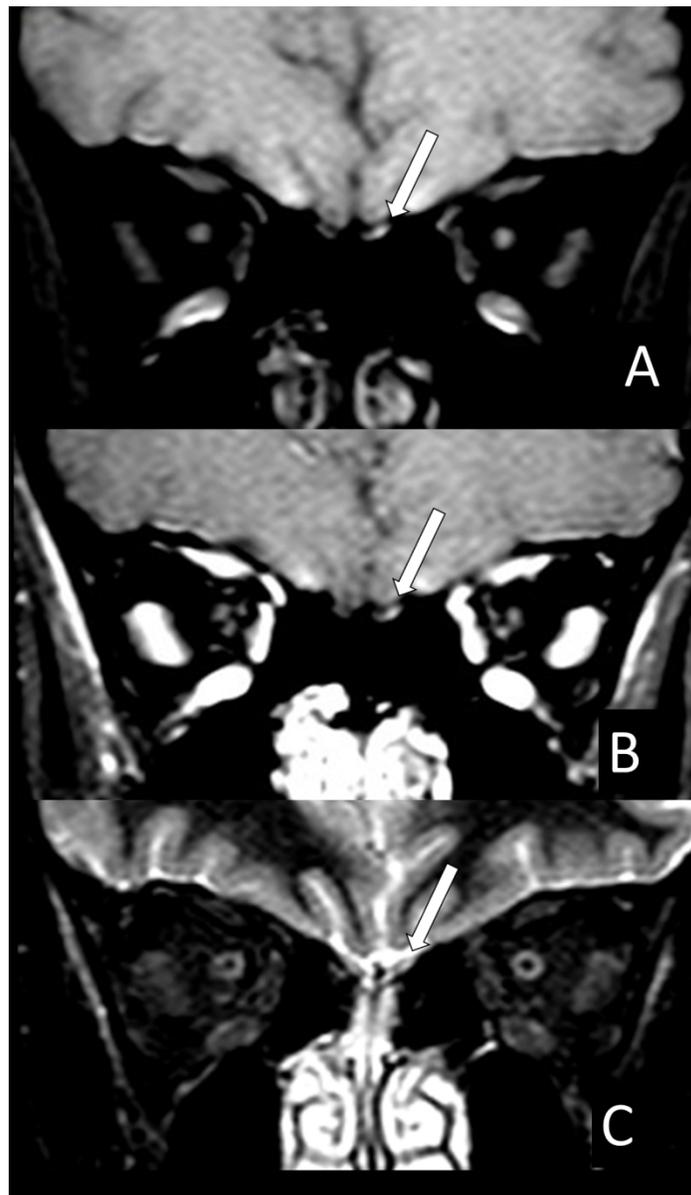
Magnetic resonance imaging shows microbleeding (methaemoglobin) in the left olfactory bulb of patient (case 1) with COVID 19 and anosmia (A-C)- The left olfactory bulb (long arrows) has partial hyperintensity on pre-contrast fat suppression T1WI (A) and also in post-contrast fat suppression T1WI (B) and STIR (C).
